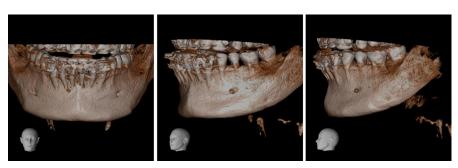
Postoperative 3D CT scan after jaw reduction demonstrating a smooth transition from the mandible angle to the chin.
